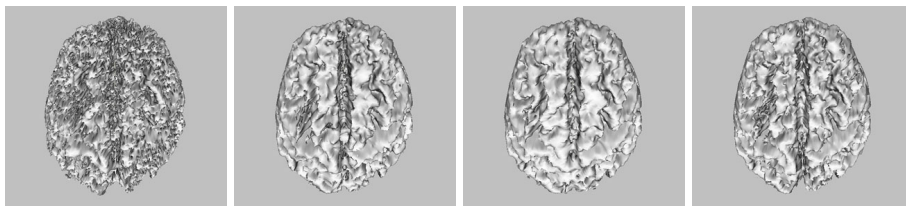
3D models of the brain (a) Simple thresholding of the original CT image (b) Bayesian classification (c) PDI (d) EM algorithm.
